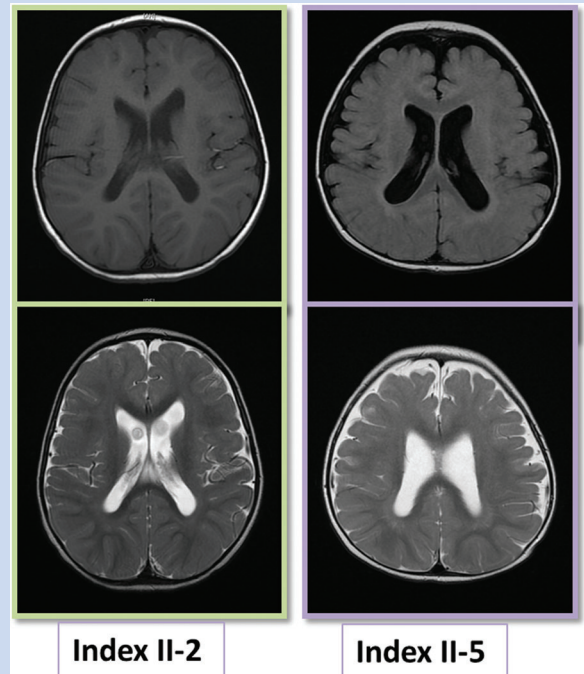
Brain MRI images of Patients II-2 (left) and II-5 (right) are presented in the figure showing signal intensity changes affecting the peritrigonal deep white matter in the parieto-occipital regions. In addition, an abnormal gyral pattern was noted in the 3D volumetric study affecting the cortex around the sylvian fissures and in the parietal lobes.
